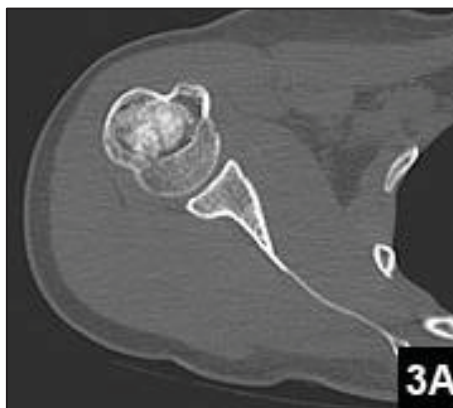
A Glenohumeral CT slice (150).
